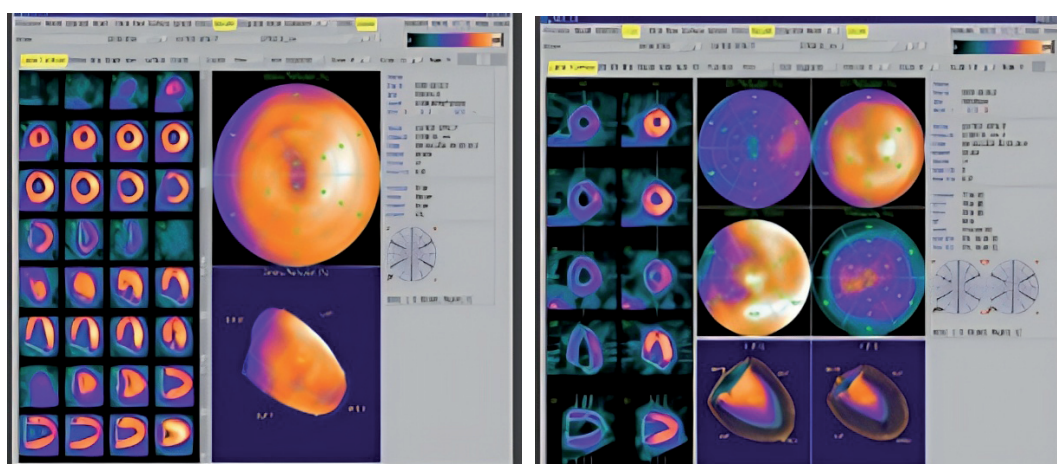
Normal scintigraphic finding. The upper image shows myocardial perfusion.
